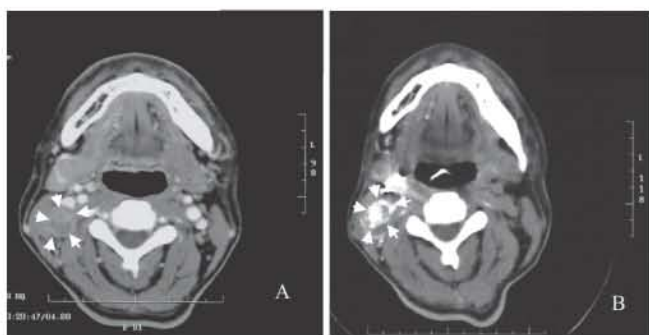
A, A 55-years-old man with lingual carcinoma (T2N1M0). A metastatic lymph node (arrows) was showed in CT scan image.
